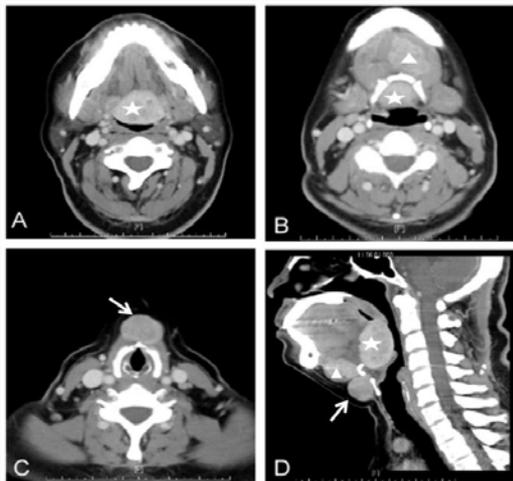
Computed tomography image of the triple ectopic thyroid including tongue base lesion (star), submental lesion (triangle) and anterior cervical lesion in front of thyroid cartilage (arrow).
